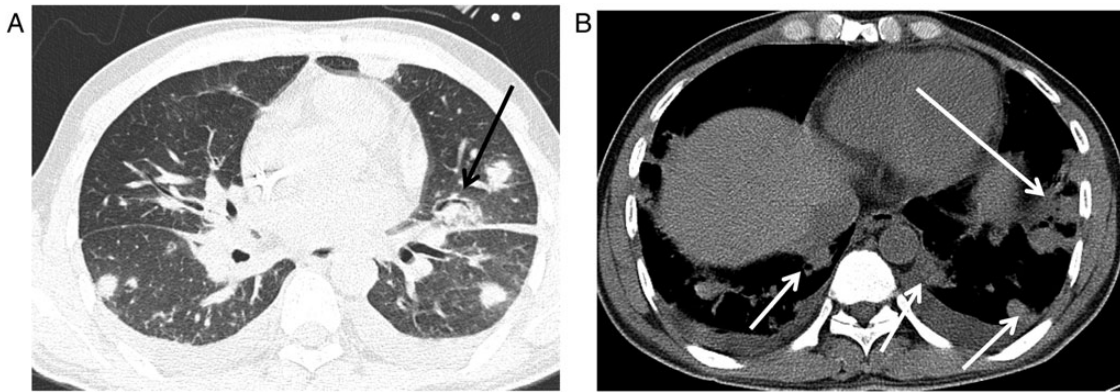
Computed tomography (CT) images obtained in a 45-year-old man with angio-invasive pulmonary aspergillosis and who had received a hematopoietic stem cell transplant 13 months previously. *A*, High resolution CT lung image (1-mm thick) obtained at the level of the lower pulmonary veins. Image shows ill-defined macronodules with halo signs in both lungs. Note the nodule with an air-crescent sign in the left upper lobe (arrow). *B*, Conventional CT mediastinal image (5-mm thick) obtained at the level of the right hemidiaphragm. The image shows bilateral pleural effusion. Note the wedge-shaped consolidations (short arrows) in both lower lobes, and the internal cavities in the lateral basal segment of the left lower lobe (long arrow), which indicates lung infarctions by angioinvasion.
